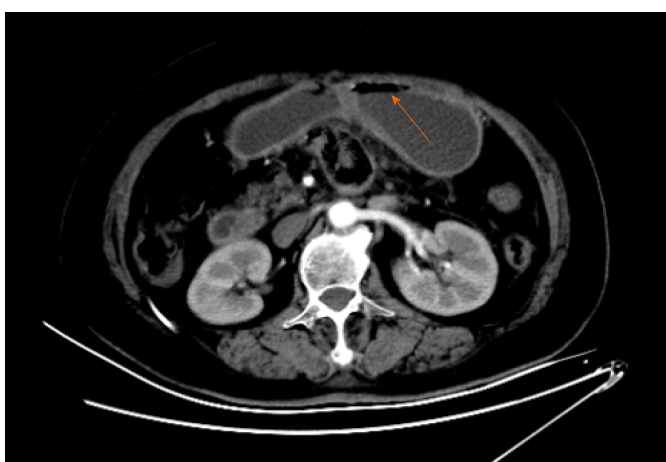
Abdominal computed tomography re-examination revealed gastric distension and loops of small intestine with multiple gas-fluid levels, which suggested intestinal obstruction.
